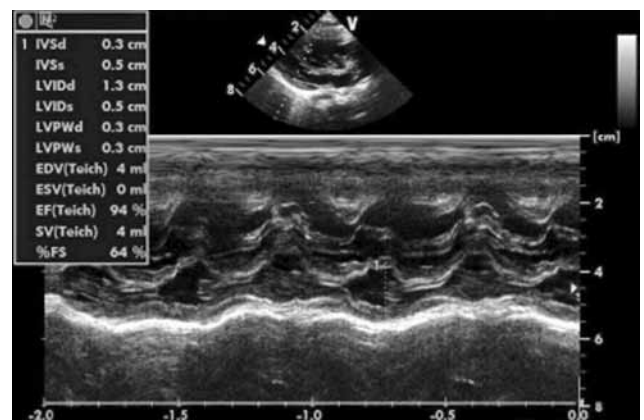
A M-mode echocardiographic image showing left ventricle involution.
